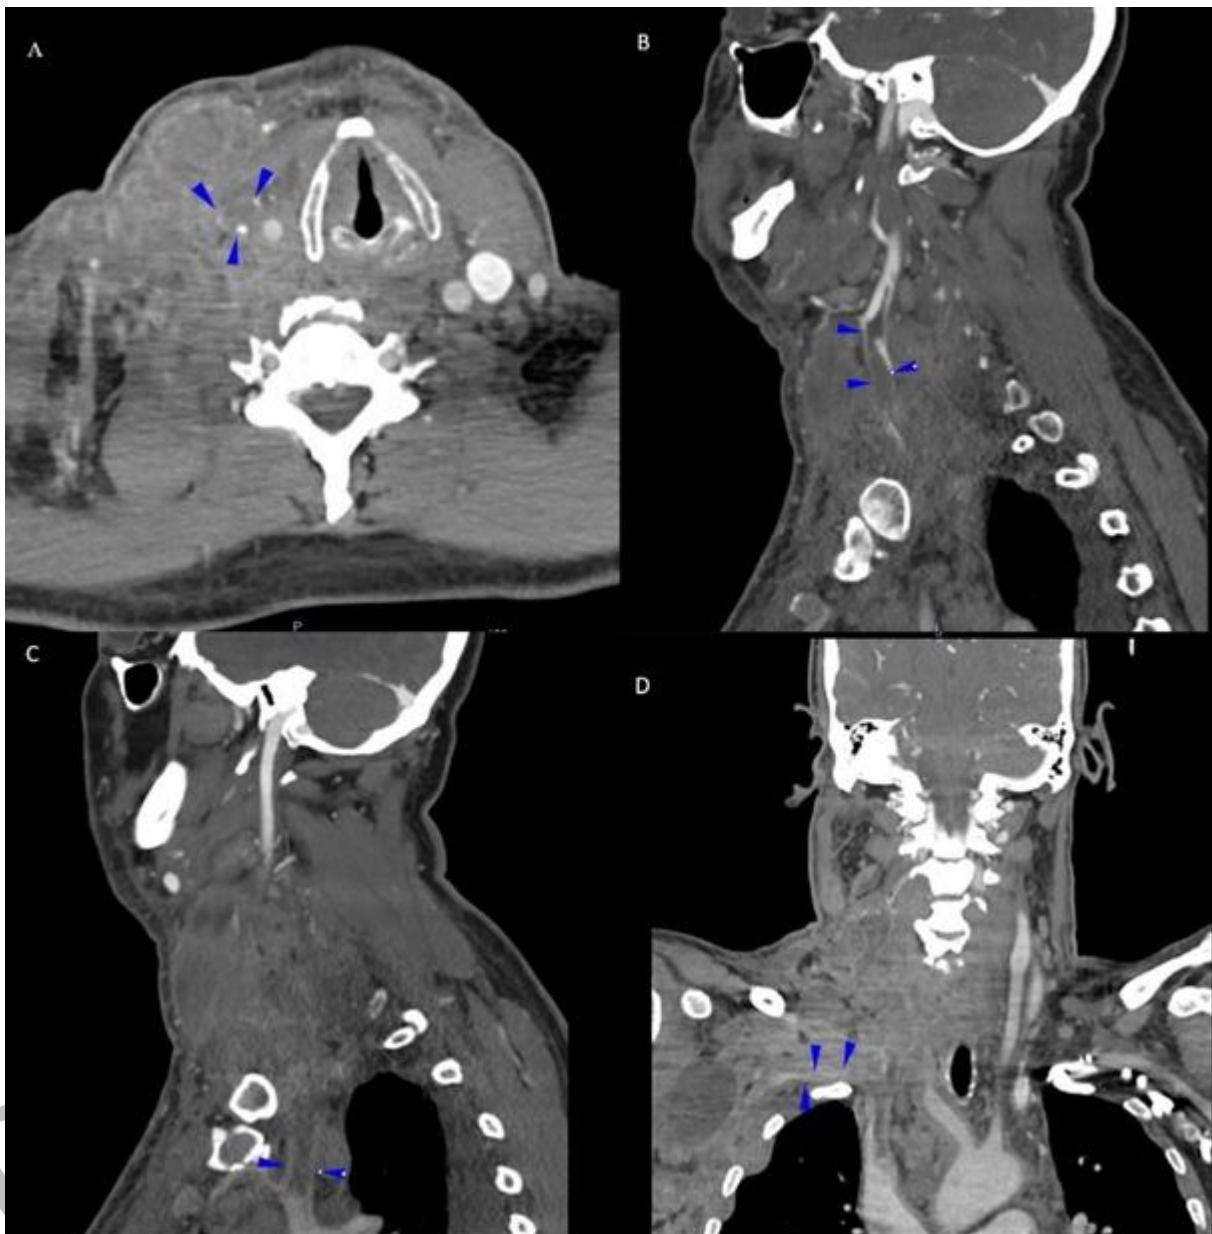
Computed tomography images; A – axial view shows right jugular vein obstruction by thrombus (arrow); B– sagittal view reveals jugular vein thrombus (arrow); C – sagittal view shows brachiocephalic vein thrombus (arrow); D – coronal view demonstrates mild extrinsic compression of the subclavian vein by the adjacent mass (arrow)
